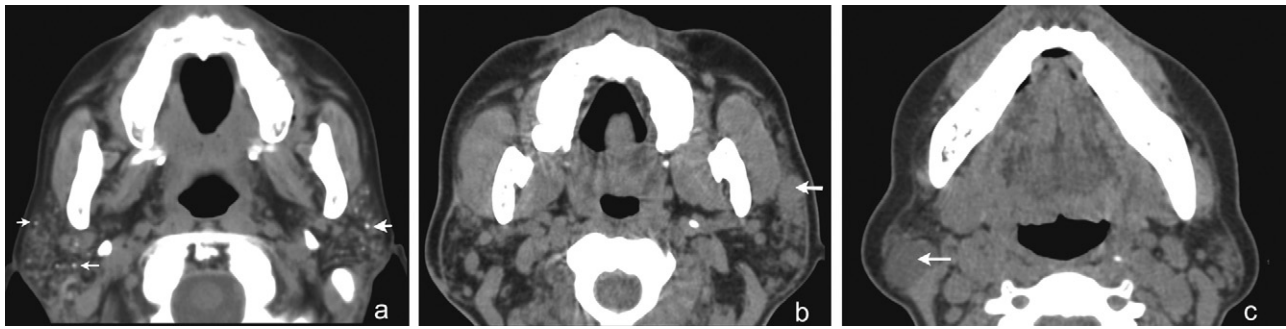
Other manifestations of parotid gland CT in SS. Diffuse punctate calcifications within bilateral parotid glands observed in SS (A, white arrows). Nodularity type of SS presents as an irregular, ill-defined area with soft-tissue attenuation in the heterogeneous parotid gland (B, white arrow). Lymphoepithelial cysts present as clearly demarcated cystic lesions with liquid attenuation (C, white arrow).
